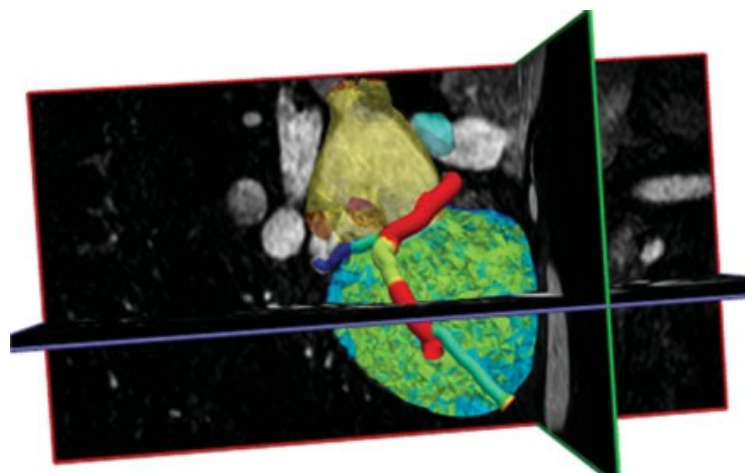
Model of the four chambers and the coronary venous tree derived from a three-dimensional whole-heart MRI data set.
